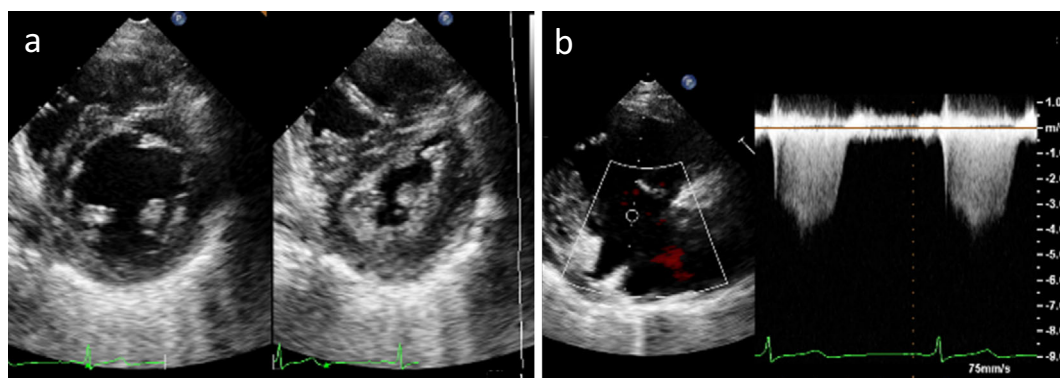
Echocardiography at the time of consultation for a further examination of breathlessness. a: Dilated right ventricle with a compressed left ventricle at the diastolic phase (short-axis view). b: Estimated right ventricular systolic pressure of 67 mmHg.
